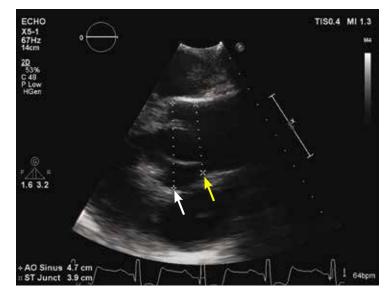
Echocardiographic image of an aneurysmal aortic root (white arrow) that tapers to normal dimensions at the sinotubular junction (yellow arrow) and ascending aorta. See videos (this image and a bicuspid aortic valve).
